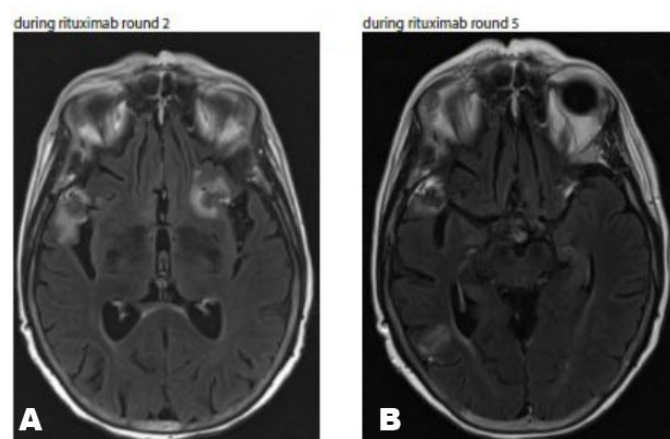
T2-weighted MRI images re-demonstrating supratentorial intra-axial masses, decreased after (A) one and (B) four rounds of chemotherapy with substantial decrease in previously noted surrounding vasogenic edema.
